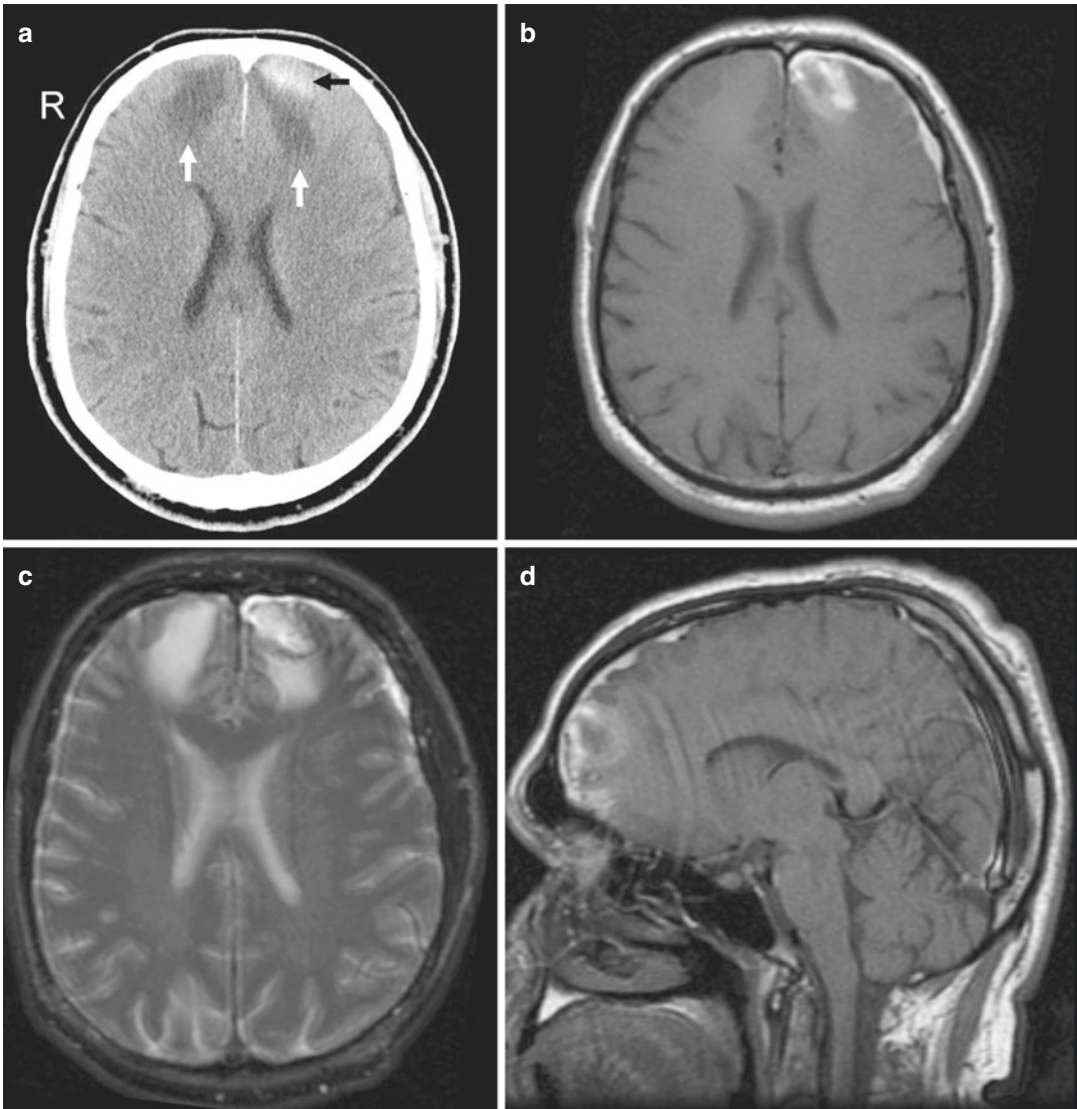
Contusion on CT and MRI. (a) Axial CT shows an amorphous high-density area within the left orbitofrontal lobe consistent with an acute contusion (*horizontal arrow*). Bilateral frontal lobe low attenuation (*vertical arrow*) represents either vasogenic edema and/or nonhemorrhagic contusion. (b) Follow-up axial T1-weighted MR image shows corresponding high signal due to the presence of methemoglobin. A thin left SDH is also noted. (c)
